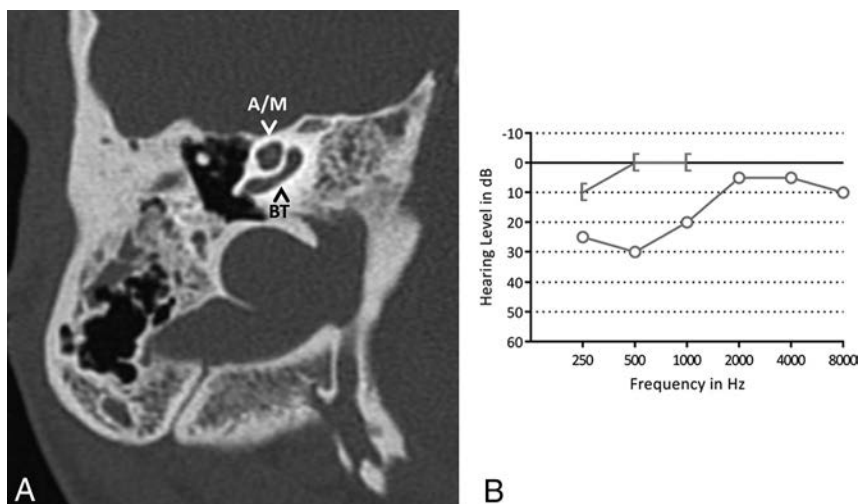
A, Axial CT image of the right mastoid shows an incomplete partition type II of the cochlea. The basal turn (BT) of the cochlea is intact; the apical and middle turn (A/M) seem confluent. B, A pure tone audiogram of the same ear shows normal hearing. The circle indicates an unmasked air-conduction threshold; the bracket, a masked bone-conduction threshold.
